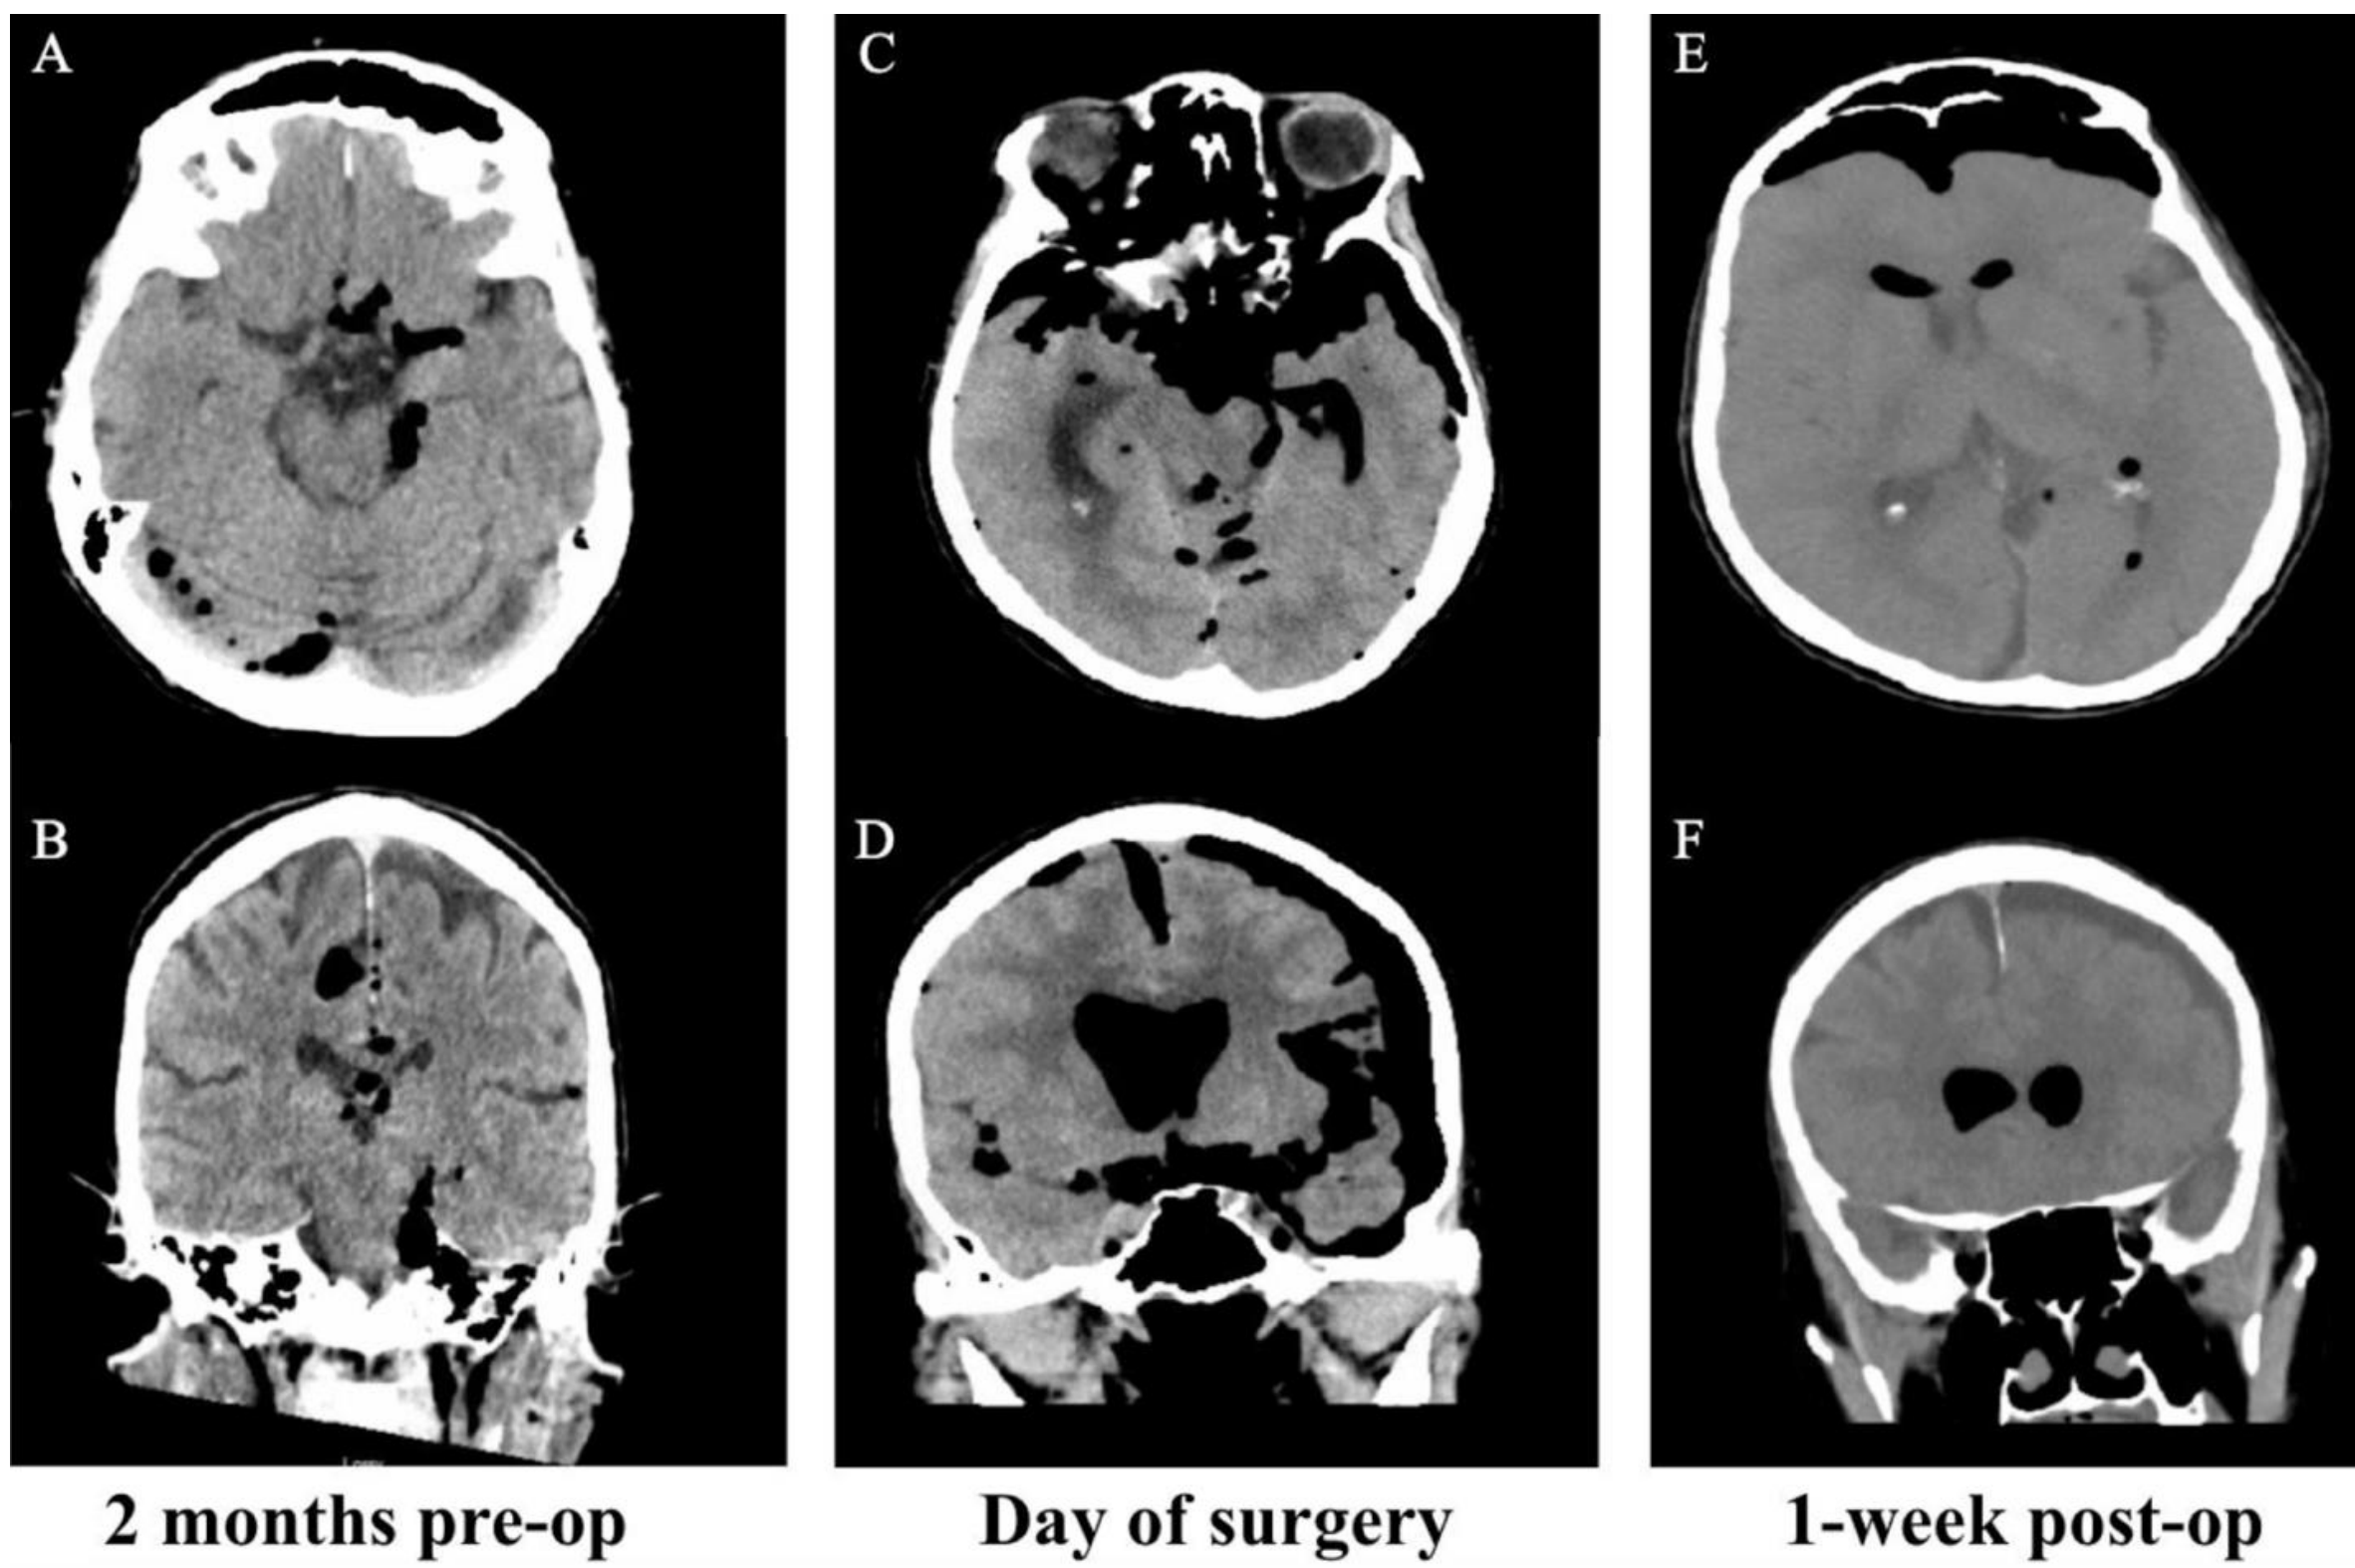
Axial and coronal sections of CT imaging without contrast 2 months preoperative (A and B), day of surgery (C and D), and 1 week post-operatively (E and F).
